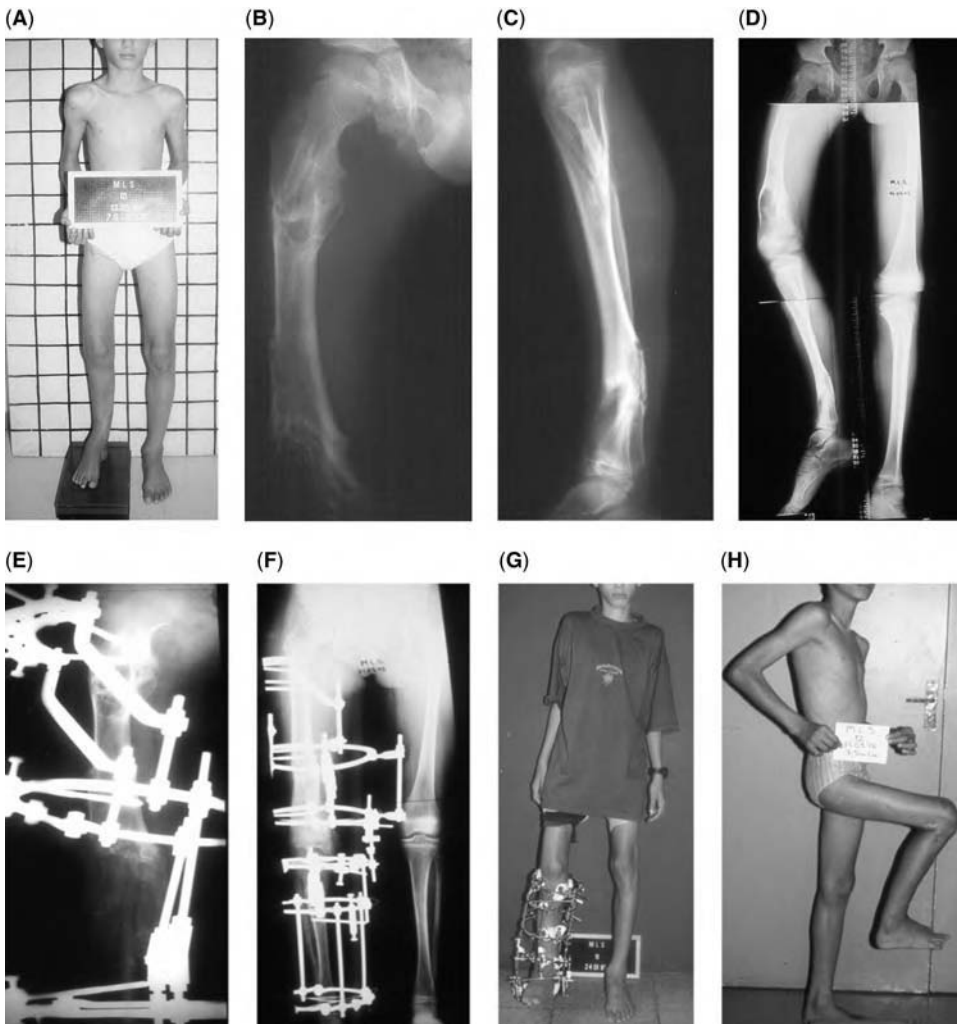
(A–D) Patient and Initial radiograph of a 12-year-old boy (showing limb length discrepancy, chondromas, and the varus and antecurvatum deformity of the right femur, and the valgus, retrocurvatum, and external rotation of the tibia). (E and F) Radiograph obtained during the treatment. (Deformities are corrected and chondroma cartilage is converted into apparently normal bone.) (G) Photograph of the patient during the elongation. (H) Final photograph of the patient (showing that the deformities and the discrepancy are corrected). (Good knee and ankle range of motion is shown).
